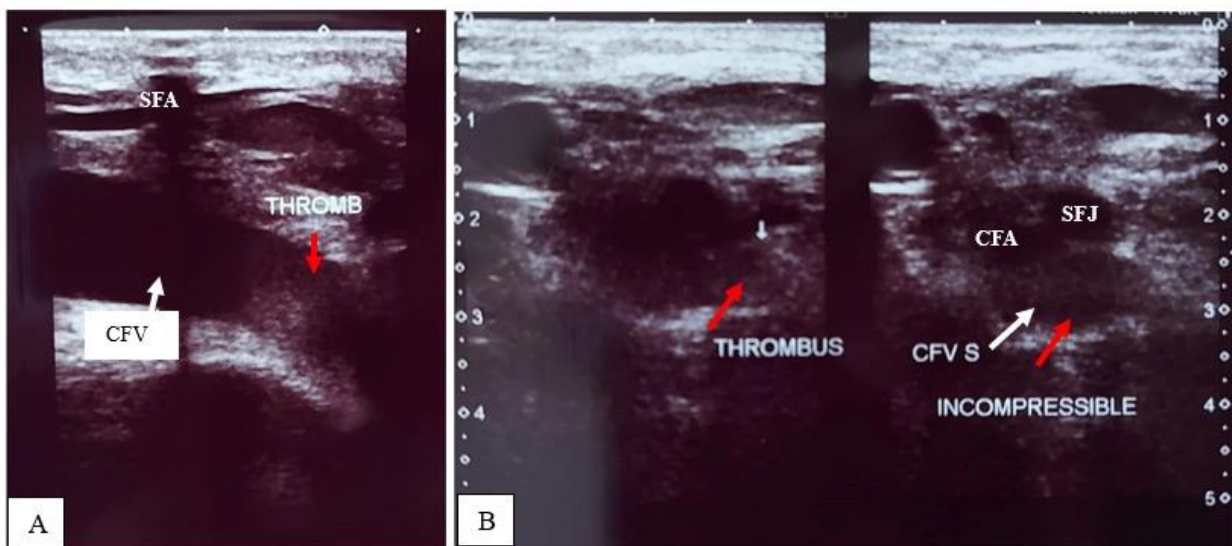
The patient's vascular duplex ultrasonography demonstrates a thrombotic filling defect, characterized by an incompressible thrombus (red arrow), along the left lower extremity vein at the left common femoral vein (CFV) with high venous flow (+). This is depicted in both the longitudinal view (A) and the transverse view (B).
